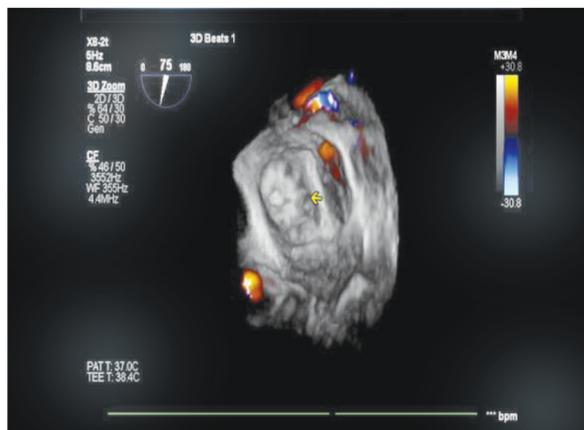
Three-dimensional color Doppler image shows appropriate device placement (arrow) with no peri-device leak.
